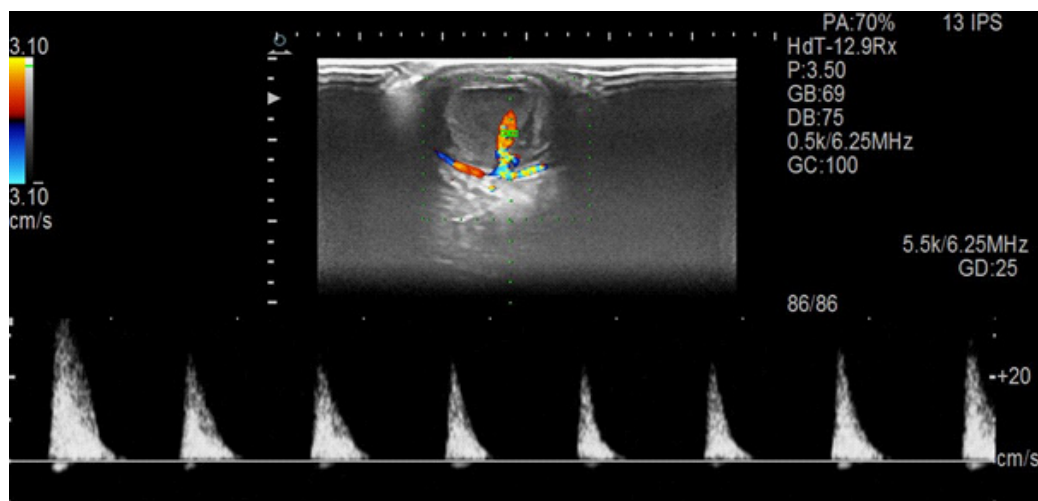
Spectral doppler waveform of arterial flow within the mass.
